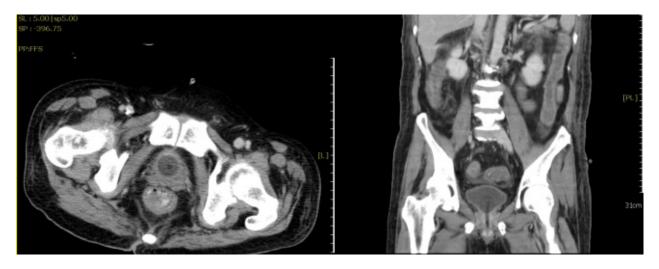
Abdominal CT post-surgery and chemotherapy: no obvious local abnormal mass is noted.
